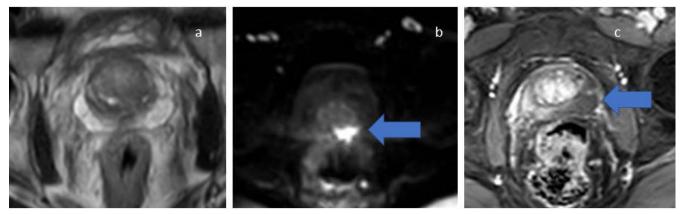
A 52-year-old man with increased prostate-specific antigen (PSA) level of 7.13 ng/mL and suspicious nodule on digital rectal examination in 2016. (a) T2-weighted axial image from the magnetic resonance imaging (MRI) of the prostate in 2016 did not show any suspicious lesion (Prostate Imaging Reporting and Data System score [PIRADS] 2). Systematic biopsy showed atypical small acinar proliferation, which was suspicious but not diagnostic for malignancy. PSA levels continued to increase, and a repeat MRI was performed in late 2018 when the PSA level was 23.81 ng/mL. (b). Axial diffusion-weighted MRI performed in 2018 showing an area of restricted diffusion in the left peripheral zone. (c) Corresponding late dynamic contrast-enhanced image showing early contrast wash-out from the lesion compared with the rest of the prostate gland. The lesion was >1.5 cm, and a PIRADS score of 5 was assigned. A repeat targeted biopsy revealed acinar adenocarcinoma, with Gleason score 3+3=6. The patient underwent radiotherapy and androgen deprivation therapy. Post-treatment PSA was 0.276 ng/mL.
